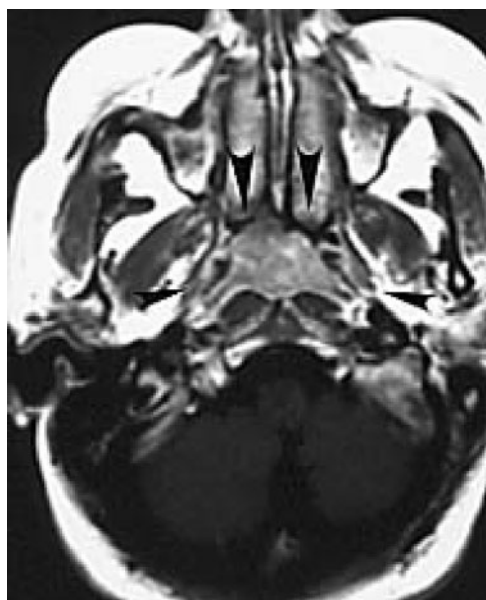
A 40-year-old woman presenting with Type 4 (anterior extension type) spread. Axial T_1 weighted MR image, Gd-DTPA enhanced, shows a nasopharyngeal tumour (arrowheads) extending anteriorly without invasion to adjacent areas.
